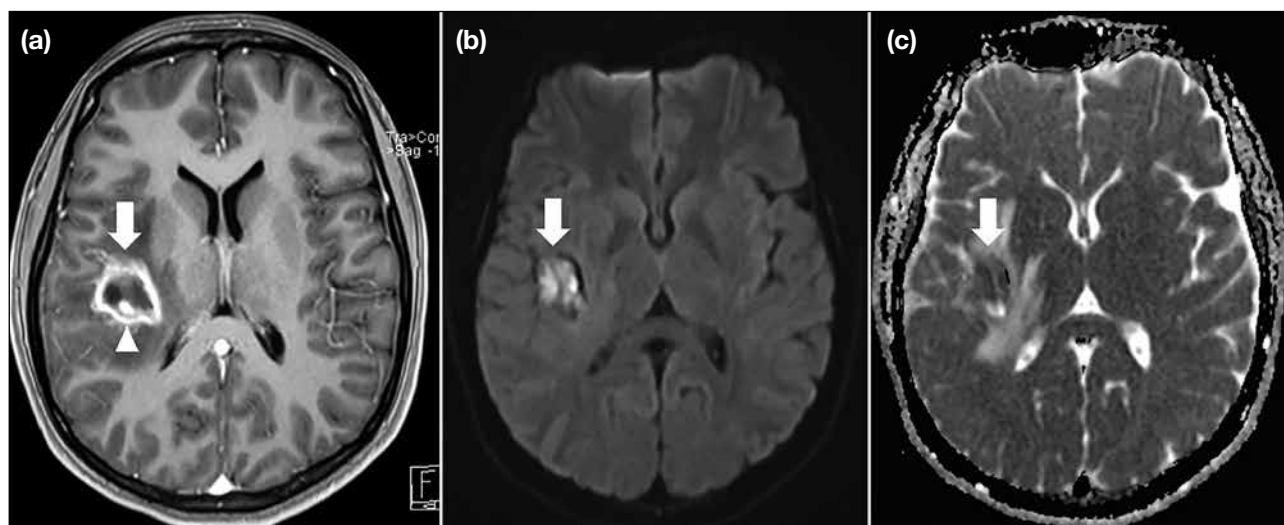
Same patient as in Figure 3. (a) Axial post-contrast T1-weighted magnetic resonance image shows a ring-enhancing lesion in the right temporoparietal region (arrow), with a central non-enhancing area and a peripheral enhancing focus (arrowhead). (b) Axial diffusion-weighted image with a high b-value demonstrates central hyperintense signal (arrow). (c) The apparent diffusion coefficient map shows corresponding hypointense signal (arrow). Overall findings are suggestive of a cerebral abscess with a mycotic aneurysm. Subsequent echocardiography revealed mitral valve regurgitation and prolapse with vegetation. Blood culture was negative. The patient underwent burr hole drainage of the abscess, and pus culture yielded *Staphylococcus aureus*. She was subsequently treated with a course of intravenous vancomycin.
